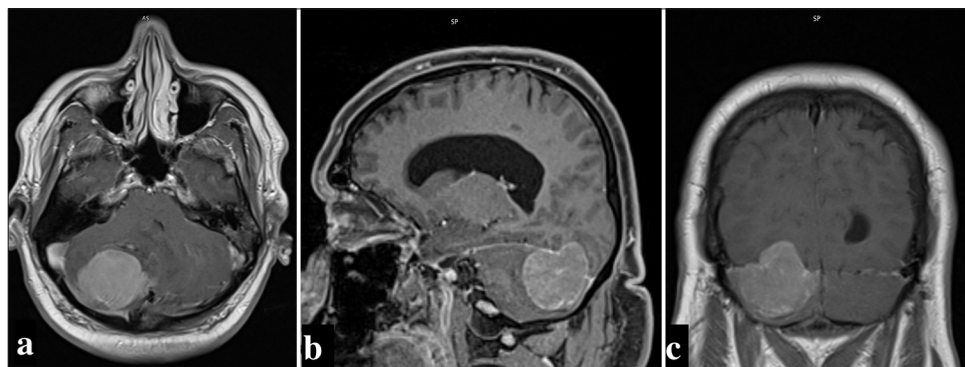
Gadolinium-enhanced magnetic resonance images depict (a) axial, (b) sagittal, and (c) coronal sections indicating a prominently enhancing mass lesion attached to the right tentorial cerebelli, with slight extension above the tentorium. The perifocal edema exerts a mass effect, causing displacement and effacement of the fourth ventricle.
